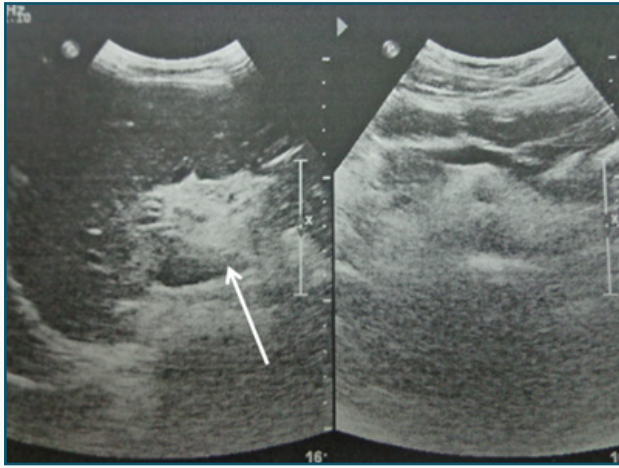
Abdominal ultrasonography with Doppler examination: absence of the portal vein which is replaced by a cluster of small veins and venules in the hepatic hil (arrow).
